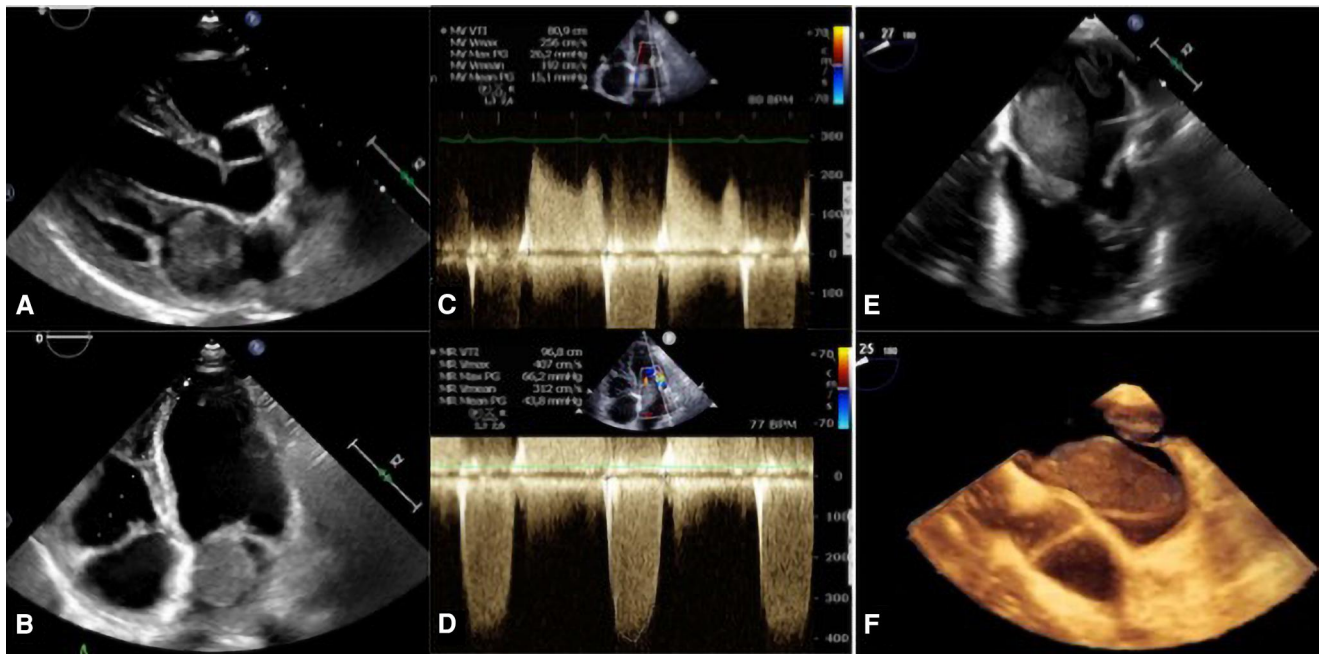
Pre-surgery transthoracic echocardiogram (A–D) and transoesophageal echocardiogram (E and F) showing three iso-echogenic regular shaped left atrial masses, the larger with $42 \times 29 \times 26$ mm apparently attached to the inferior portion of the inter-atrial septum and protruding into the left ventricle in diastole. This mass causes severe obstruction to the left ventricular filling (C) with mean gradient of 15 mmHg and mitral valve area by pressure half-time of 0.83 cm^2 and also impaired mitral leaflets coaptation with at least moderate mitral regurgitation around the mass (lateral vena contracta of 6.6 mm) (D). There was also high probability of pulmonary hypertension and right ventricular dysfunction: peak tricuspid regurgitation velocity of 4.0 m/s (mean right ventricle/right atrium gradient of 64 mmHg), pulmonary artery dilation (diameter of 33 mm), right ventricular outflow tract acceleration time of 84 ms, systolic and diastolic D shape of left ventricular and right ventricular dilation (basal diameter of 41.2 mm), hypertrophy (free wall of 6.5 mm), and dysfunction (fractional area change 14%, tricuspid annular plane systolic excursion 16 mm).
